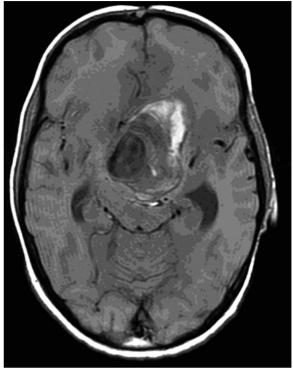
A) Sagittal contrast enhanced MRI shows a giant aneurysm of the left distal internal carotid artery. B) Axial unenhanced T1-weighted MRI showing mural thrombus and signs of acute mural hemorrhage.
